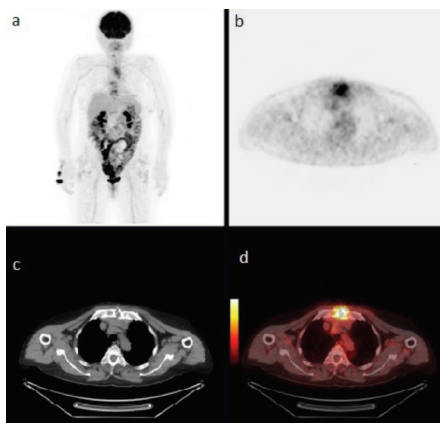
a) Maximum intensity projection, b) transaxial PET image, c) transaxial CT image, d) transaxial PET/CT fusion image
